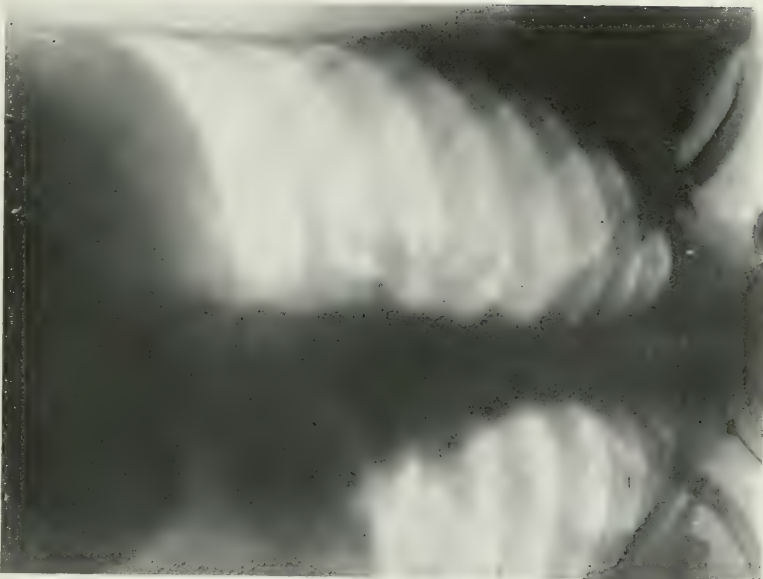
X-ray showing expanded lung filling left thoracic cavity. Picture taken three months after operation.
